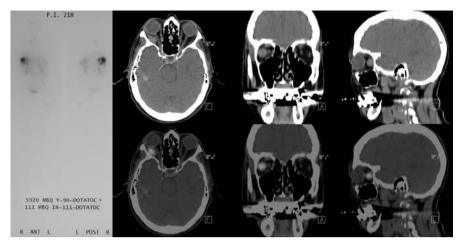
Patient with neuroendocine and unusual single metastasis in the eye muscle. Irradiation with ¹¹¹In- / ⁹⁰Y-DOTATOC. Planar scintigraphic imaging on the left side, SPECT/CT fusion imaging on the right side of the picture.
